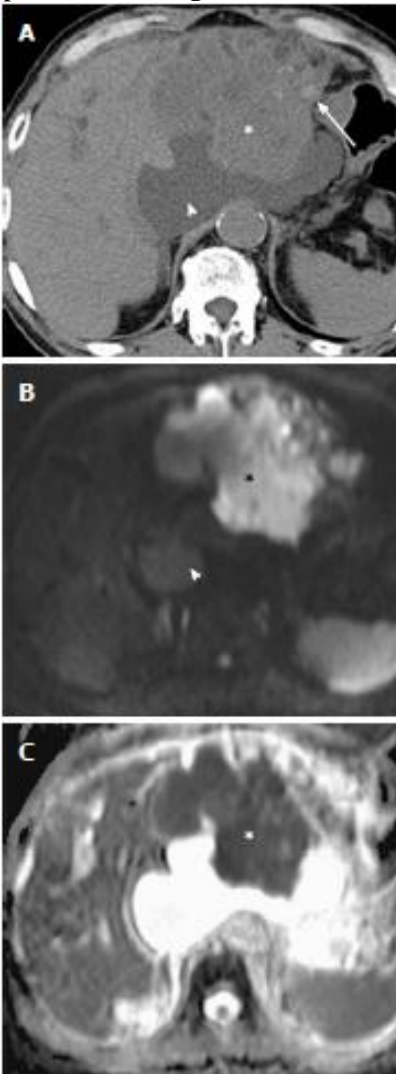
intrahepatic cholangiocarcinoma (mass-forming type) in a 71-year-old man. A: Non-enhanced CT image shows intrahepatic cholangiocarcinoma in the left lobe of the liver (asterisk), stones in the dilated left bile ducts (arrow), and a fluid collection in the lesser sac (arrowhead); B: DWI at $b = 1000 \text{ s/mm}^2$ shows
